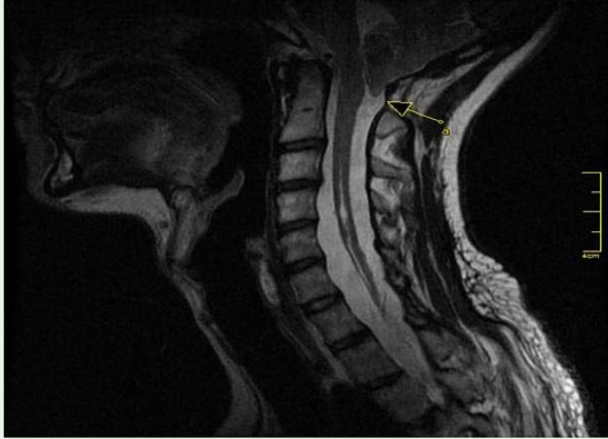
Cervical Magnetic Resonance Imaging. A: Cerebellar tonsils are herniated through the foramen magnum and the caudal brainstem compression is seen.
